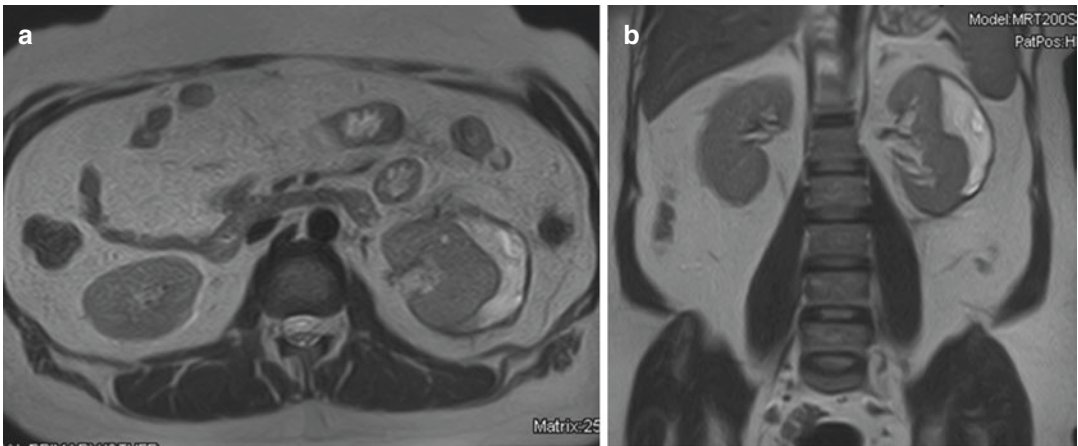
Same patient. Follow-up magnetic resonance imaging (MRI) 1.5 months later: Compared to previous controls, there is a further significant reduction in the subcapsular hematoma thickness of the left kidney. HASTE T₂-weighted sequences axial (a) and coronal (b); fat-sat VIBE T₁-weighted sagittal scan (c). The hematoma appears hyperintense with some small hyperintense areas inside resulting from the different stages of the degradation of hemoglobin
